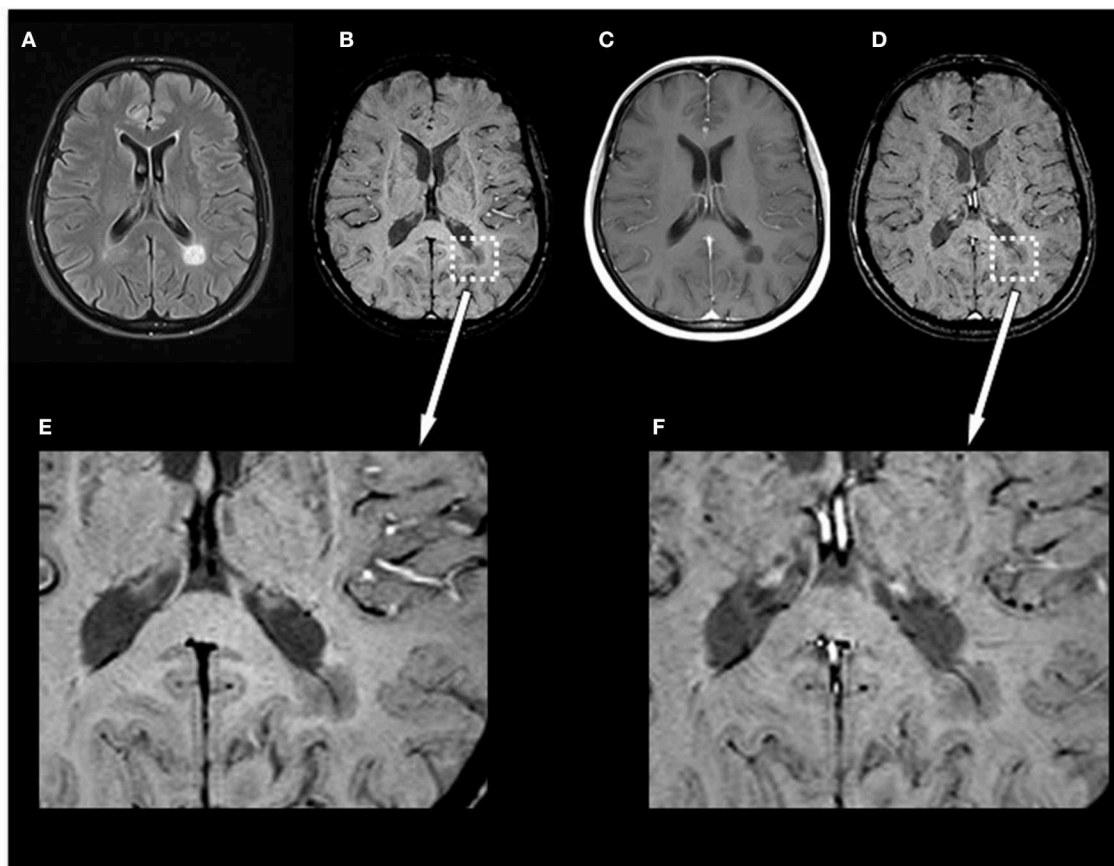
Exemplary MRI of a 44-year-old woman presenting with relapsing–remitting MS. (A) T2-FLAIR, (B) pre-contrast SWI and magnification (E), (C) post-contrast T1-weighted (T1w), and (D) post-contrast SWI and magnification (F). Conventional MRI demonstrates a chronic T1-hypointense lesion (“black hole”) that appears homogeneously hypointense on SWI. Post-contrast SWI (D) and magnification (F) facilitated the visibility of the penetrating vein already seen in pre-contrast images but had no influence on the total number of veins detectable or diagnostic image quality and parenchymal signal alterations. MS, multiple sclerosis; FLAIR, fluid-attenuated inversion recovery; SWI, susceptibility-weighted magnetic resonance imaging.
